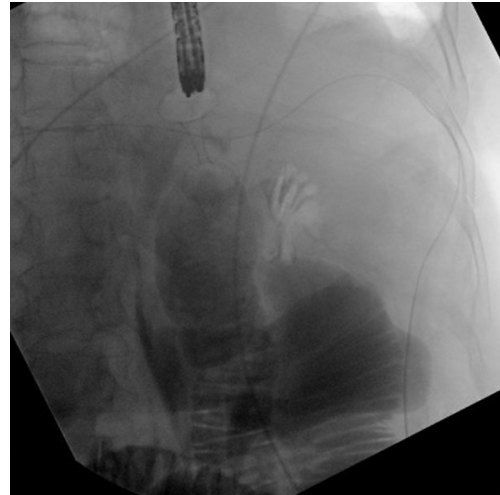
X-ray fluoroscopy post-LAMS placement in case 1.
